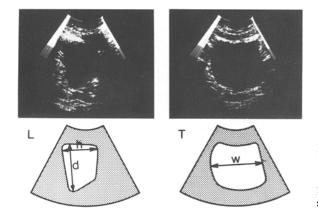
Determination of bladder height (h), depth (d) from the longitudinal, and of width (w) from the transversal ultrasound section
